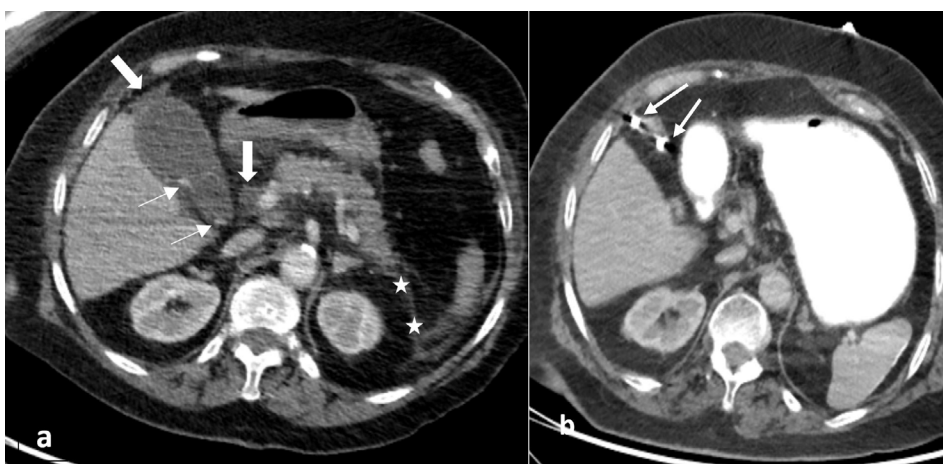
Acute calculous cholecystitis caused by biliary acute pancreatitis. A 45-year-old female patient presented to the emergency department with the right upper quadrant pain. Computed tomography (a) shows gallbladder wall thickening, hydrops, and calculous opacities in its lumen (thin arrows). Poorly limited free fluid and thickening are observed at the level of the anterior perirenal fascia on the left, adjacent to the gallbladder fundus and pancreatic head (thick arrows). The patient was treated with the percutaneous cholecystostomy method (b). Arrows demonstrate drainage catheter.
